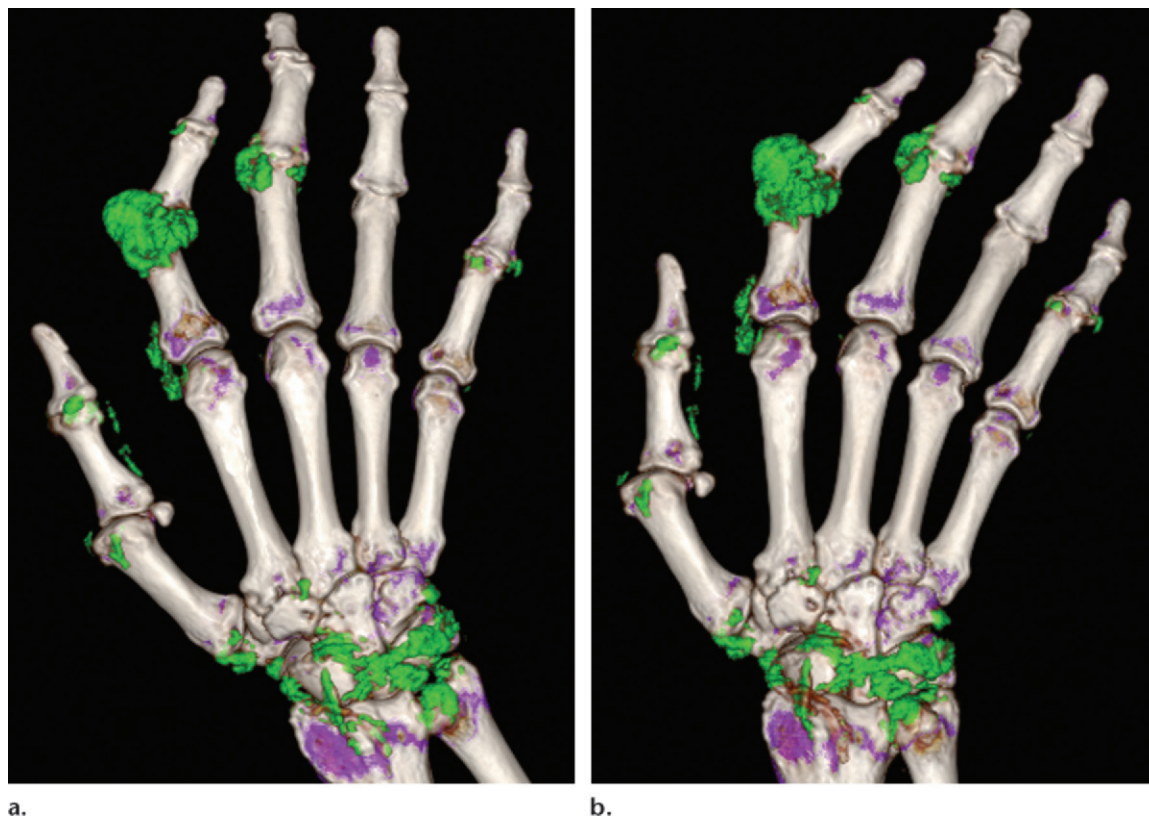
Determination of change in tophus burden at serial dual-energy CT. Images were obtained 6 weeks apart. Visually, the changes in tophus burden are difficult to compare because of differences in positioning and the small amount of change present. Serial dual-energy CT images with volumetric analysis show a tophus burden with a volume of 10.78 cm³ (a) and 9.95 cm³ (b), findings that represent an 8.3% decrease in tophus burden, a change that corresponds to medical treatment and an interval drop in serum urate level, from 624.6 to 493.7 μ mol/L (10.5 to 8.3 mg/dL).
